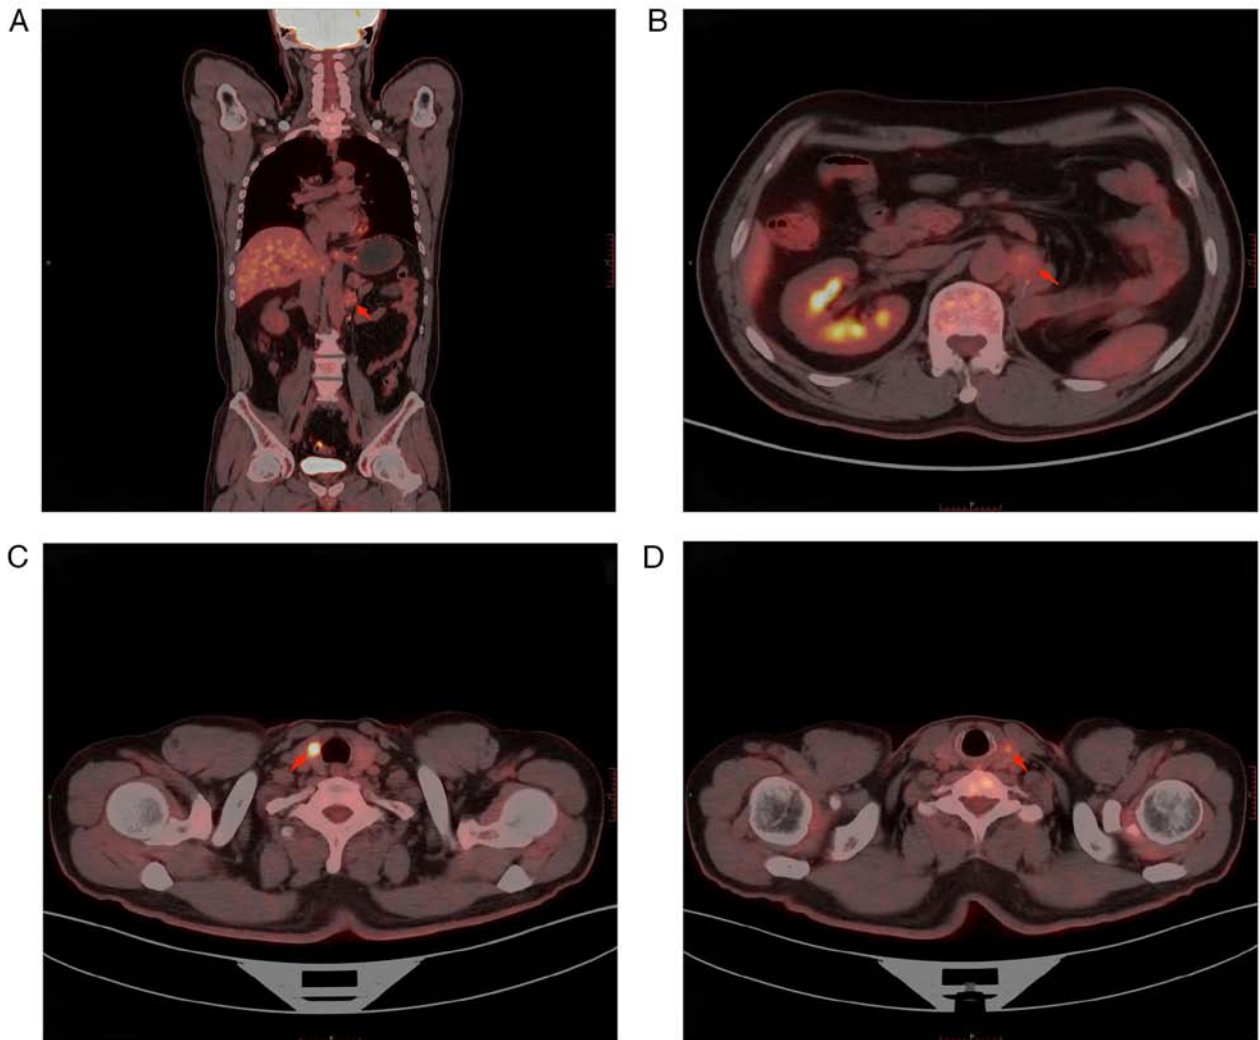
Positron emission tomography-computed tomography in November 2021. (A) Coronal section demonstrated that the left kidney and left adrenal gland are not shown. A soft tissue density nodule (red arrow) is seen on the left side of the abdominal aorta and there were no swollen lymph nodes in the remaining pelvic abdominal cavity. (B) Transverse sections demonstrated that a soft tissue density nodule of $\sim 2.3 \times 2.0$ cm² in size (red arrow) on the left side of the abdominal aorta. The margin of the nodule are poorly demarcated with the left crus of the diaphragm. The imaging agent intake increased unevenly. SUV_{MAX} was ~ 3.1 . (C) Nodule of the right lobe of the thyroid (red arrow): Poorly defined border, significantly increased imaging agent uptake, SUV_{MAX} of ~ 12.2 . (D) Nodule of the left lobe of the thyroid (red arrow): Border clear, slightly increased imaging agent uptake and SUV_{MAX} of ~ 3.1 . SUV_{MAX} , maximum standard uptake values at the PET scan.
